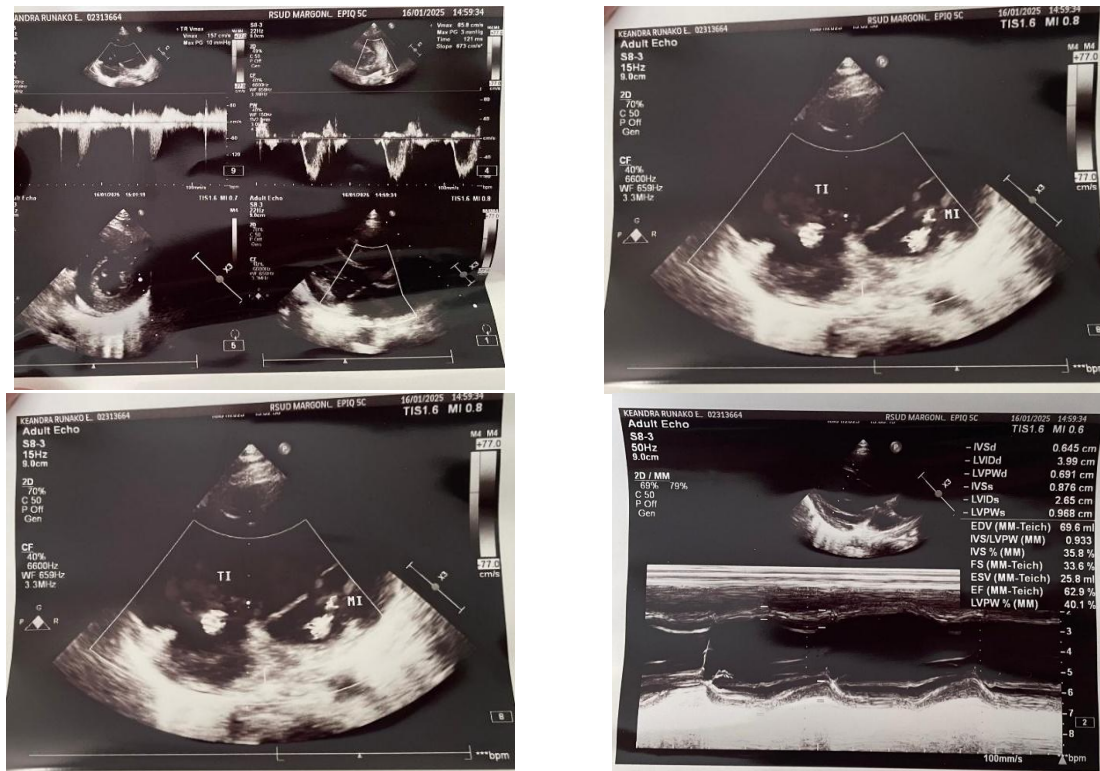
Echocardiographic Findings from RSMS (January 16, 2025)
